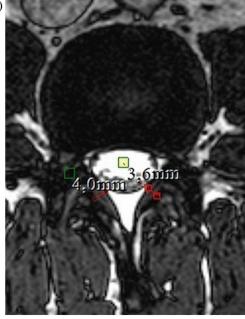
MRI images in axial planes show (a) laminectomy defect (arrows) and (b) measurements on the MRI of a 45-year-old male patient one year post-surgery in the L3-4 disc space.
